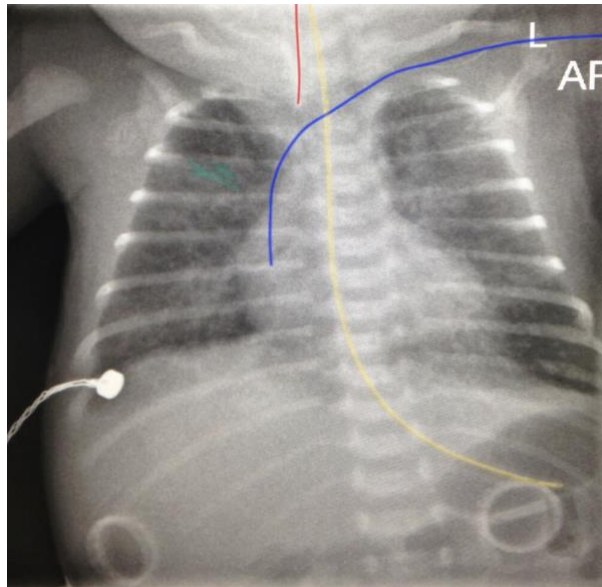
RDS. X-ray chest (AP view). Lungs show a diffuse granular pattern with low volumes. Air bronchogram (green overlay) can be seen. Endotracheal (red) and nasogastric (yellow) tubes are present. There is also a left central line (blue). Adapted from: [83].
